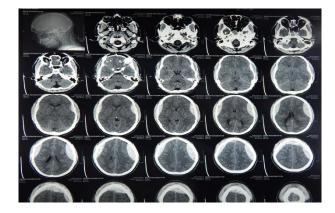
(B): Preoperative CT scan brain of case 3.
